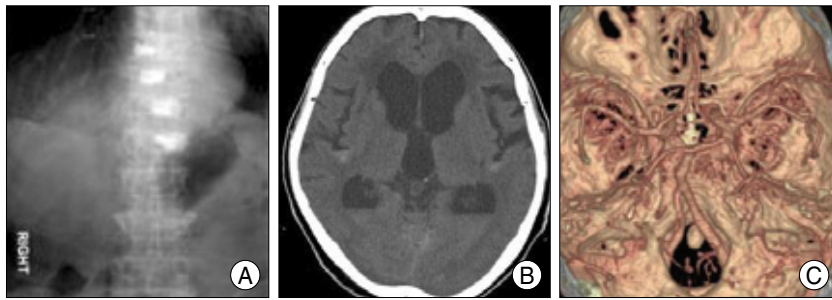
A 74-year-old woman with multiple compression fractures on the dorsal and lumbar spines treated by vertebroplasty. Cement radioopacities are noted in the thoracolumbar spine bodies (A). Subarachnoid hemorrhage and intraventricular hemorrhage is demonstrated on cerebral computed tomography scan after spine procedure (B). Three-dimensional computed tomography angiography does not depict any vascular abnormalities (C).
